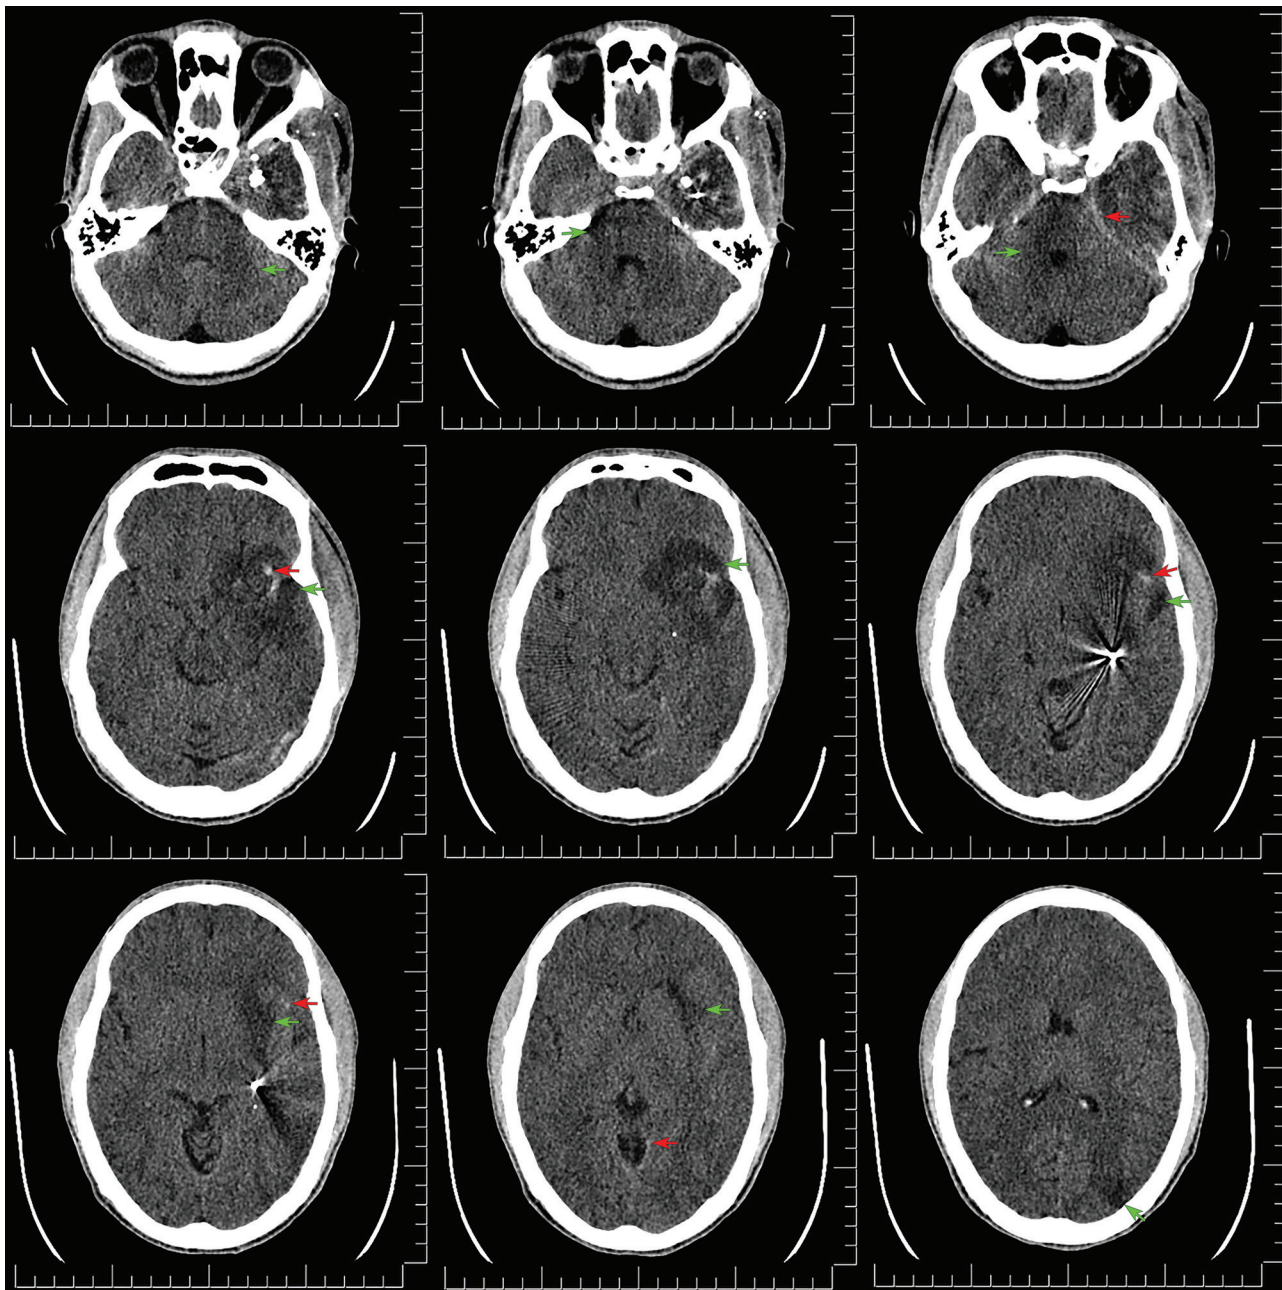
Axial slices of head CT without contrast in the brain window show a decrease in bleeding in the frontal, parietal and left temporal subarachnoid spaces (red arrows), with a notorious increase in vasogenic edema (green arrows) in comparison with the previous image.
